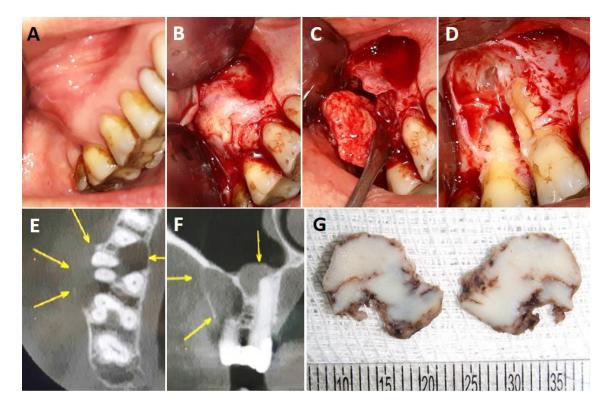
Clinical and radiographic features of central odontogenic fibroma, granular cell variant (case 4): (A) Intraoral examination revealed expansion of vestibular bone cortice of posterior maxilla without tooth displacement. (B-D) Intraoperative images showing the close relation between the lesion and roots of involved teeth. (E-F) CT images showing a perirradicular bilocular radiolucency in the posterior maxilla with expansion and disruption of bone cortices. (G) Gross appearance showing a smooth-surfaced nodular mass measuring 1 cm, with whitish cut surface and fibroelastic consistency.
